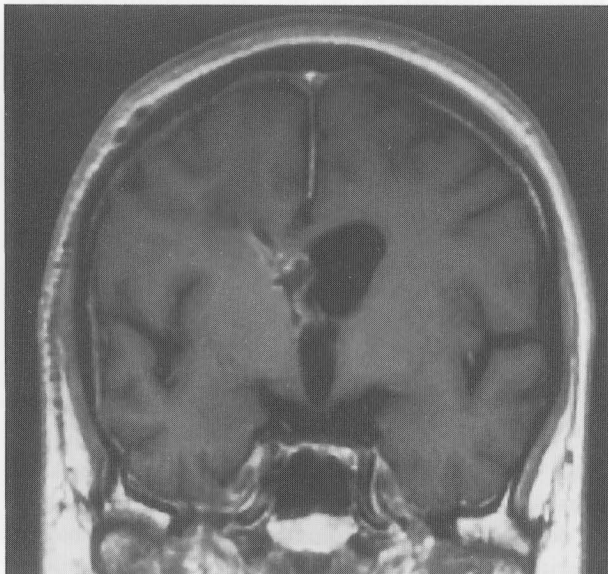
Postoperative T1-weighted gadolinium-enhanced MR image showing a large tumor in the right lateral ventricle subtotally removed.
